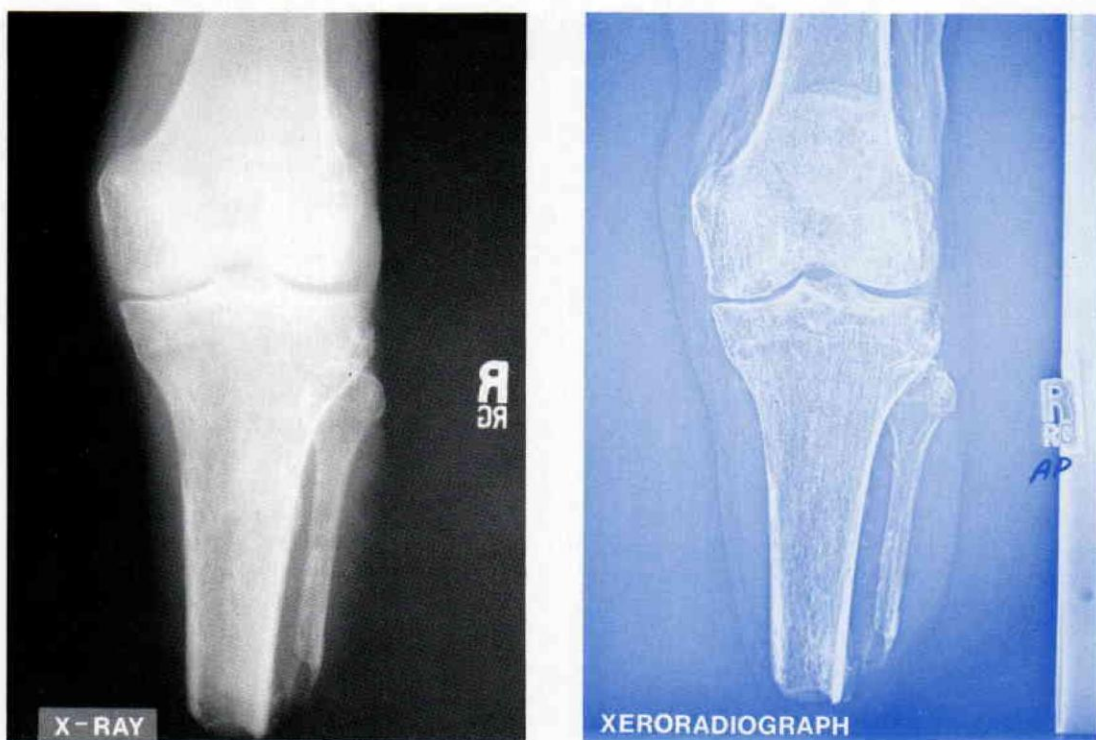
Comparison of bone detail and clarity of soft tissue margins on a conventional film radiograph versus a Xeroradiograph® of the same residual limb. Note magnification of the x-ray image.
